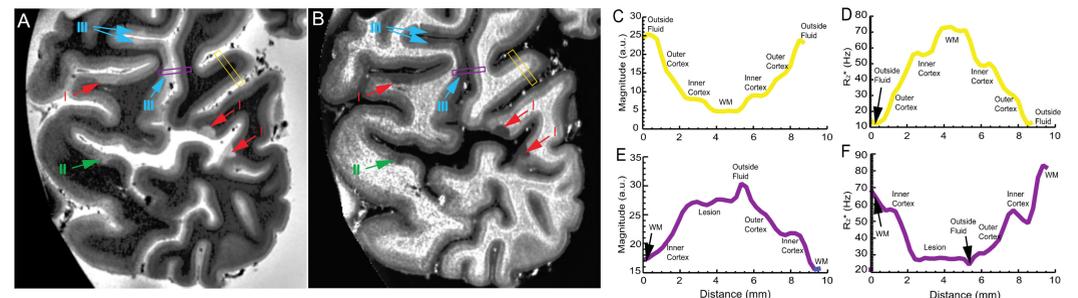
Examples of NLs from tissue MS-2 identified on MRI (A) magnitude and (B) R₂* images. Arrows point towards different types of NLs. Examples of intensity profiles on both magnitude (C, E) and R₂* maps (D, F), corresponding to the yellow (C,D) and purple box regions (E, F, cross through a NL), respectively.
